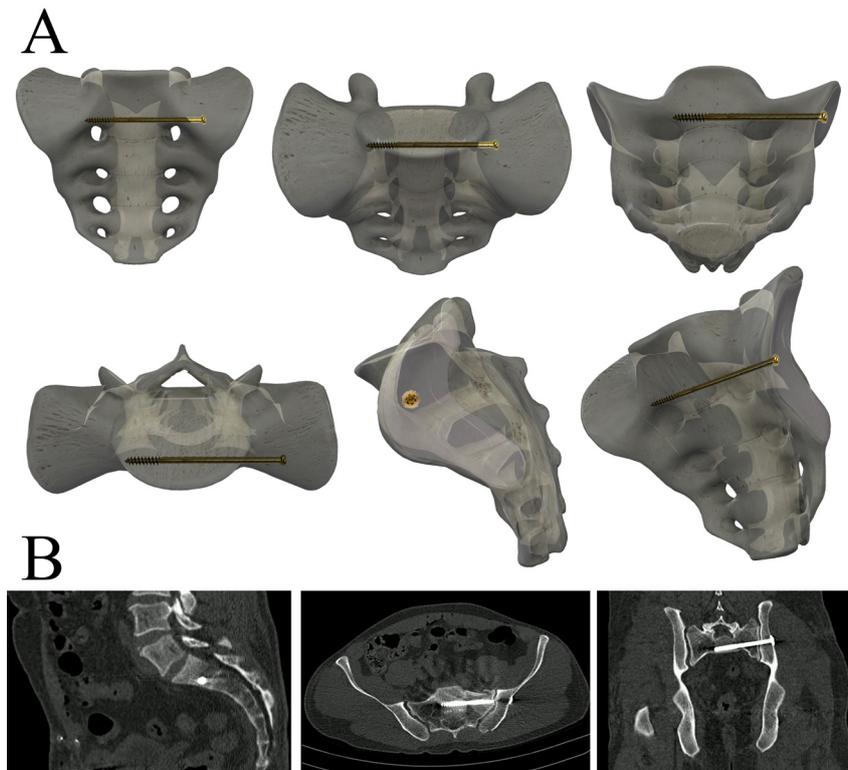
S1 screw in the most anterior and lowest part of the S1 vertebra. 3D transparent model of the sacrum (A) and postoperative sagittal, coronal, and axial CT scan (B) showing the position of the S1 screw in different views.
